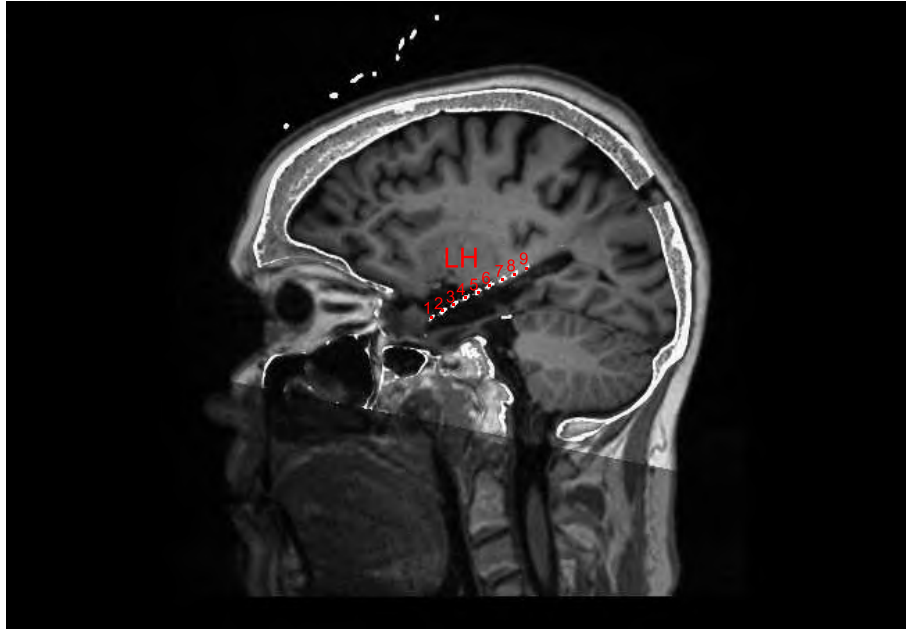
Merged post-operative MR image and pre-operative CT image showing the electrode positions with respect to the resected brain area. LH1 to LH5 laid within the resected area, LH6 laid on the border of the resected area.
